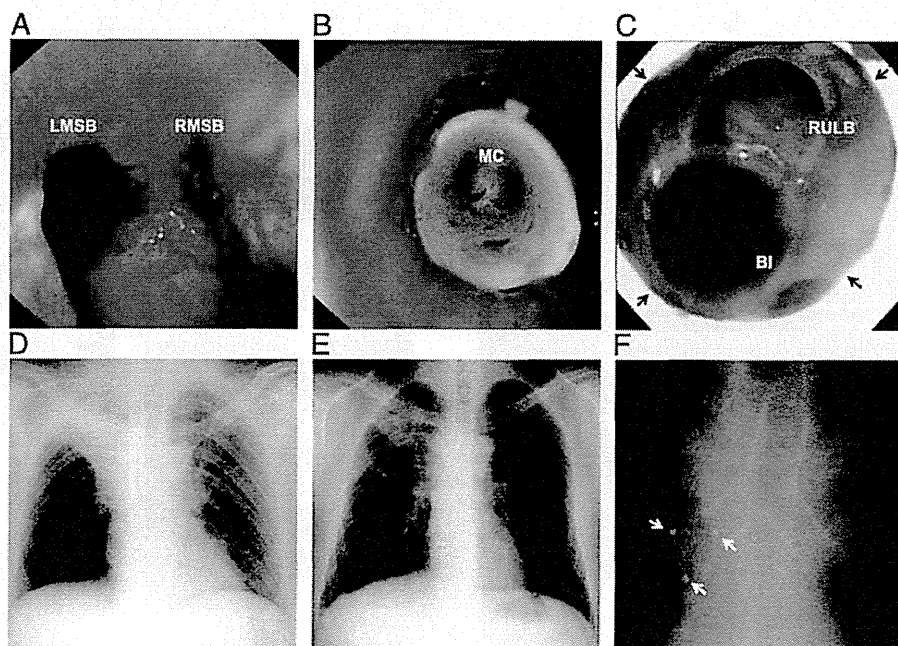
Bronchoscopic views and chest roentgenograms of patient 8 in Tables 1 and 2. A, Bronchoscopic view before stent placement, showing the trachea and the RMSB invaded by lung cancer (squamous cell carcinoma). B, Bronchoscopic view of additional radiopaque Y stent on the main carina. C, Bronchoscopic view of the primary right carina after stent placement. The right main bronchial limb (arrows) of the additional Y stent was inserted into the right main stem bronchial limb of the study stent. D, Chest roentgenogram before stent placement, showing atelectasis of the right upper lobe lung. E and F, Chest roentgenograms after stent placement. Radiopaque studs (arrows) of the study stent and a Y stent can be seen. See Figure 2 and 4 legends for expansion of other abbreviations.
